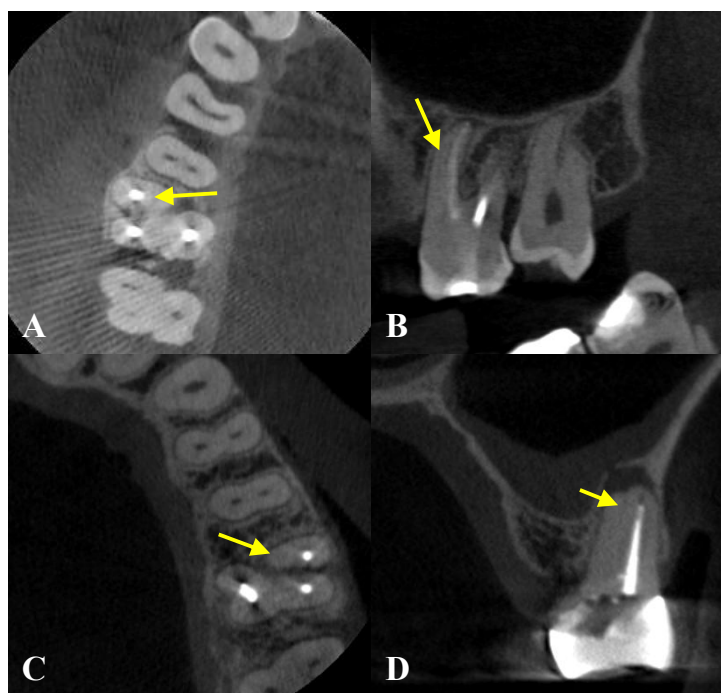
(A and B) CBCT images of two maxillary first molar teeth with four canals as seen from the axial and sagittal views. The yellow arrows show the missed MB canals. (C and D) Endodontically treated maxillary first molar tooth with four canals as seen from the sagittal and axial views. The yellow arrows show a missed MB canal. Also noted from the sagittal view is the periapical lesion associated with the MB root.
